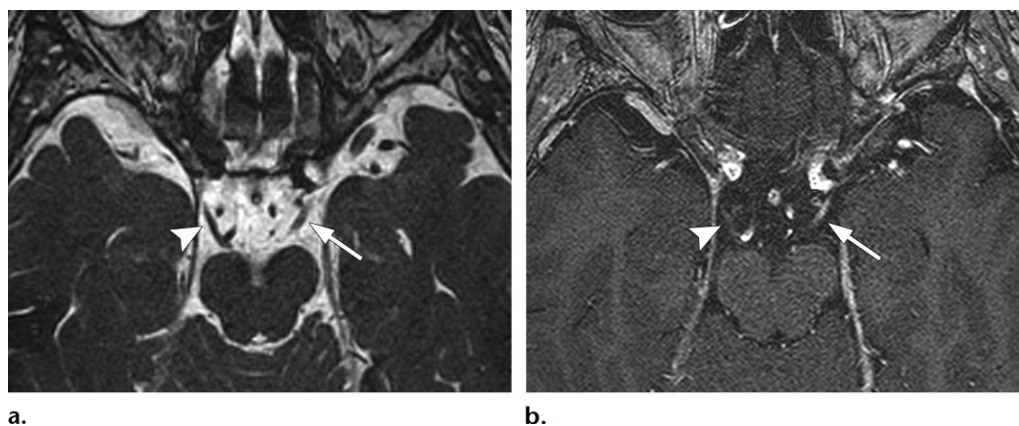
Cranial neuropathy in a 72-year-old woman with diplopia and ptosis of the left eye. She underwent stereotactic radiosurgery for a left cavernous sinus meningioma 4 years earlier. (a) Axial fast imaging employing steady-state acquisition (FIESTA) image shows the cisternal portions of the left (arrow) and right (arrowhead) oculomotor nerves. (b) Axial contrast-enhanced T1-weighted image shows marked enhancement of the left oculomotor nerve (arrow), in contrast to that of the right oculomotor nerve (arrowhead).
